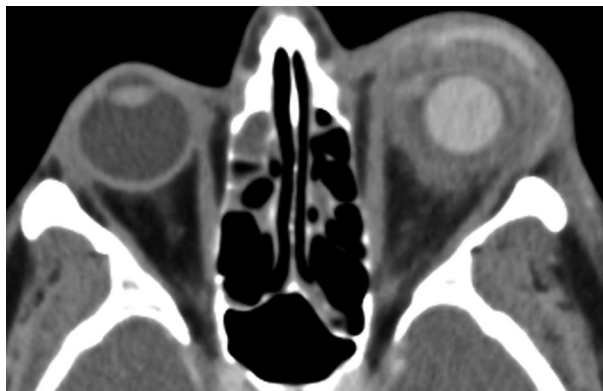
Axial CT shows marked soft tissue swelling involving the anterior orbit and eyelids. No abscess is evident.
